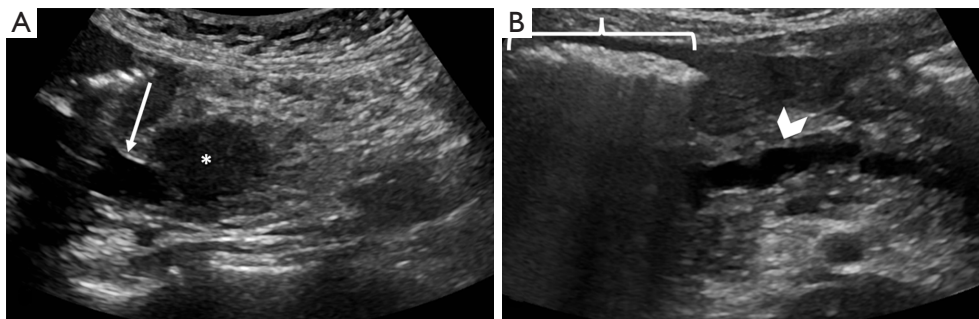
US of pancreas head mass. (A) US in a 46-year-old woman with right upper quadrant pain demonstrates a 3.1 cm hypoechoic mass (asterisk) causing biliary duct dilation (arrow). (B) During portions of the exam, the mass is obscured by overlying bowel gas (bracket) while a dilated pancreatic duct remains visible (chevron). US, ultrasound.
